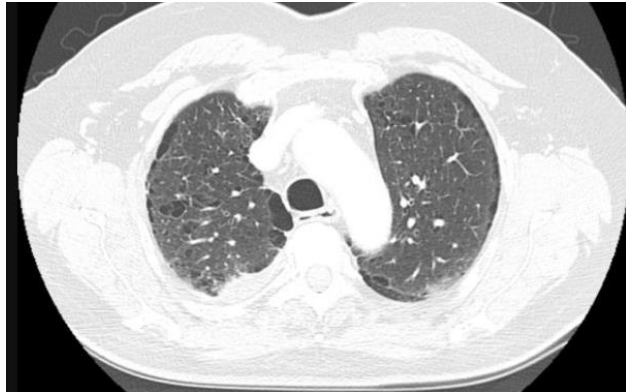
Axial HRCT Thorax with paraseptal Emphysema
